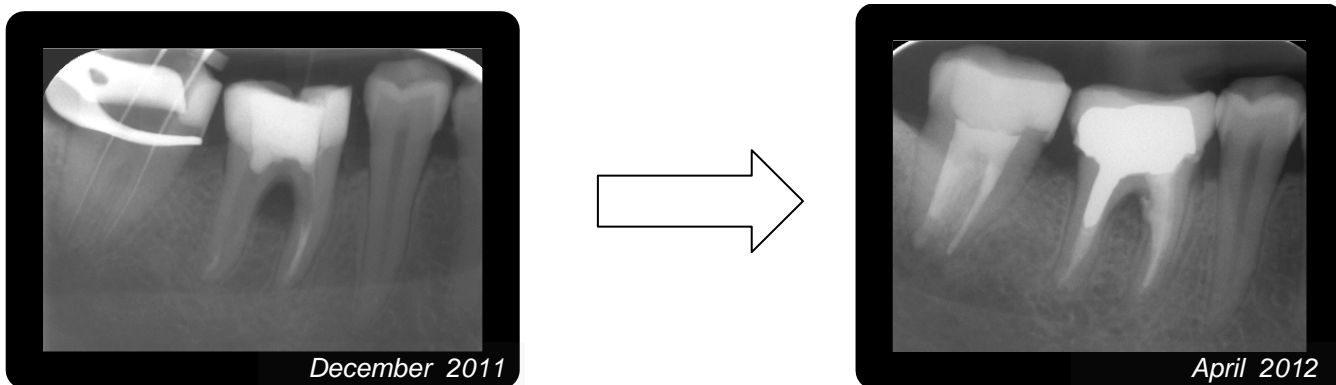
Radiographs for comparison before treatment and 4 months after treatment
